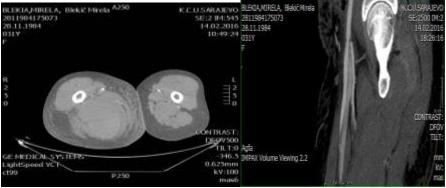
CTA showed progression in the size of the hematoma with propagation to the distal third of the back of the leg, to the right
